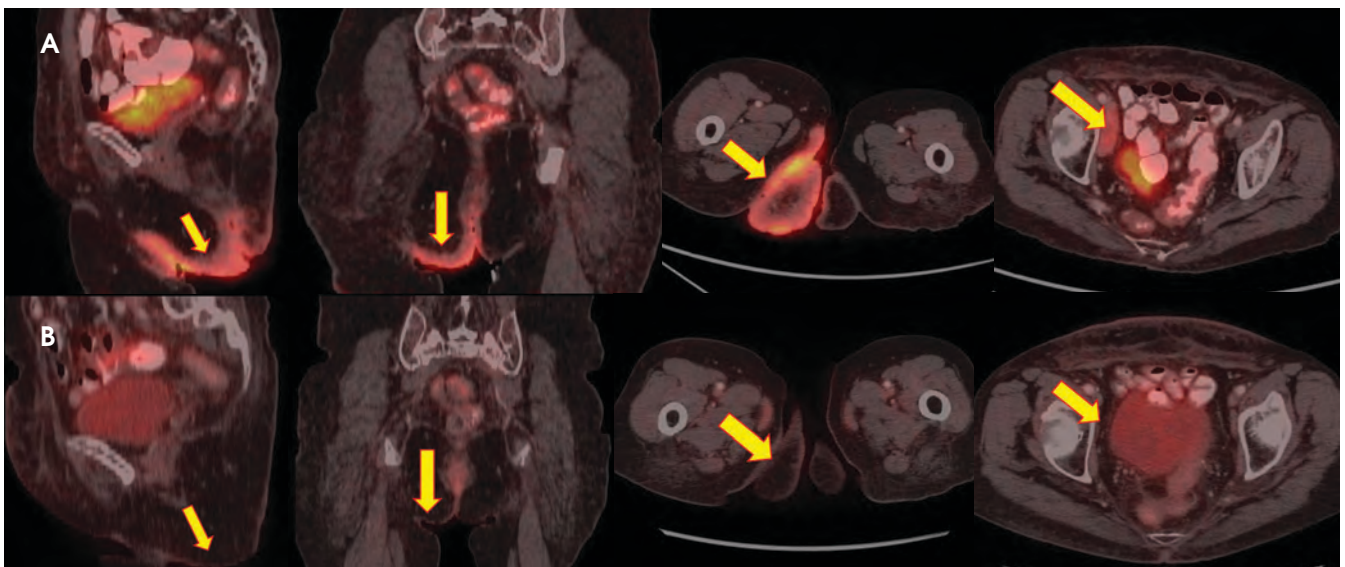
Positron emission tomography – computed tomography (PET-CT) (pre-treatment) showing a large area of metabolically active diffuse cutaneous thickening involving the right gluteal region extending anteriorly up to inguinal region, perianal region, and vulva with pelvic lymphadenopathy (yellow arrow) (A). Post-treatment PET-CT shows complete locoregional response (yellow arrow) (B).
